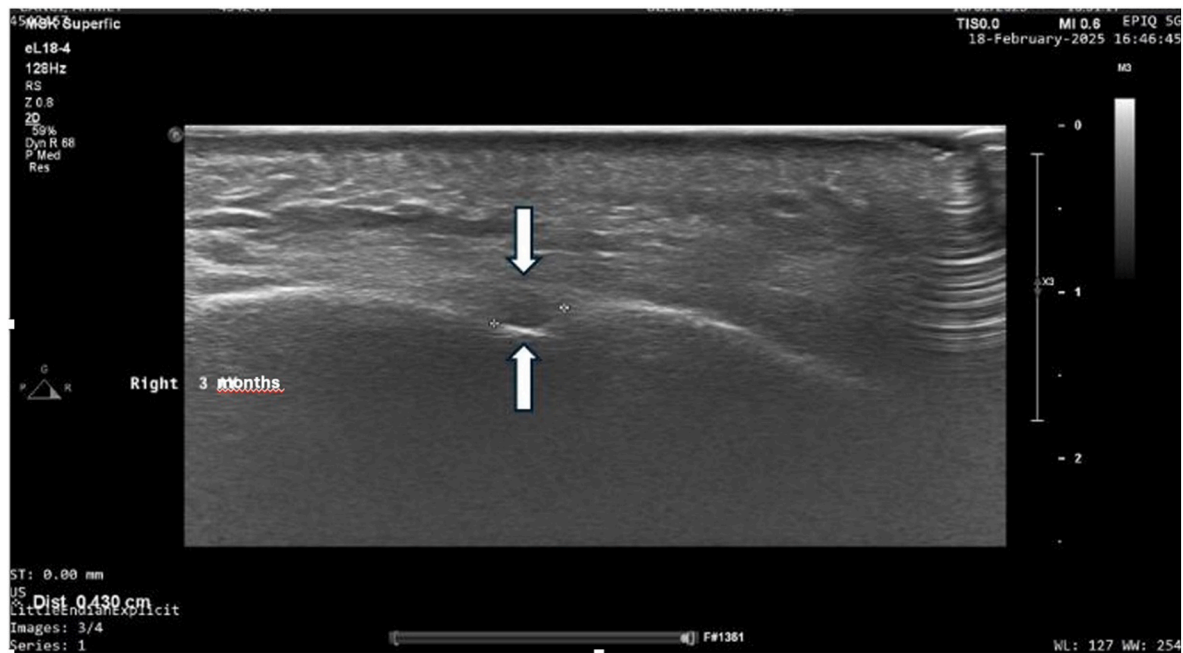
Ultrasound image showing the right mental foramen (white arrow) and the measurement of its transverse diameter using a high-frequency linear transducer.
